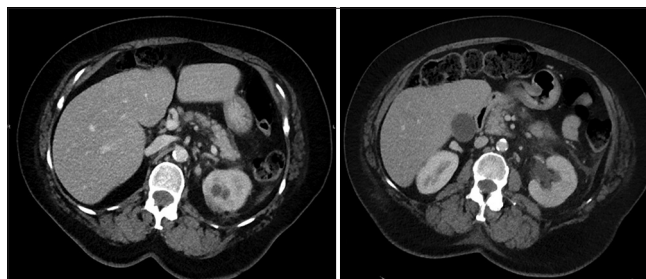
A 60-year-old female who presented for follow-up imaging 6 months after the removal of a second drain placed for recurrent emphysematous pyelonephritis. CT abdomen with contrast shows resolution of emphysematous pyelonephritis findings. Perinephric stranding is less conspicuous and represents chronic scarring. More cranial slice is pictured on the left with more caudal slice on the right.
